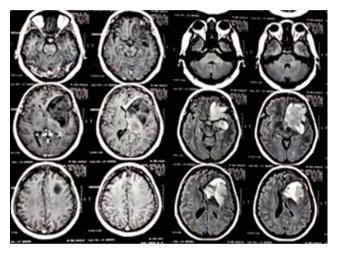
Magnetic resonance imaging showing evidence of frontal lesion.
